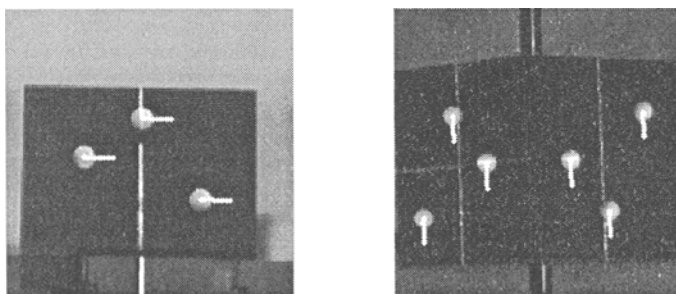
The target for the tracking experiment consisted of six white spheres mounted to two orthogonal planes. The white lines on the images indicates the position of the spheres in subsequent images. Such a device could be incorporated into CT treatment planning images and, with the calibrated video system, aid in the positioning of patients for radiation therapy.
